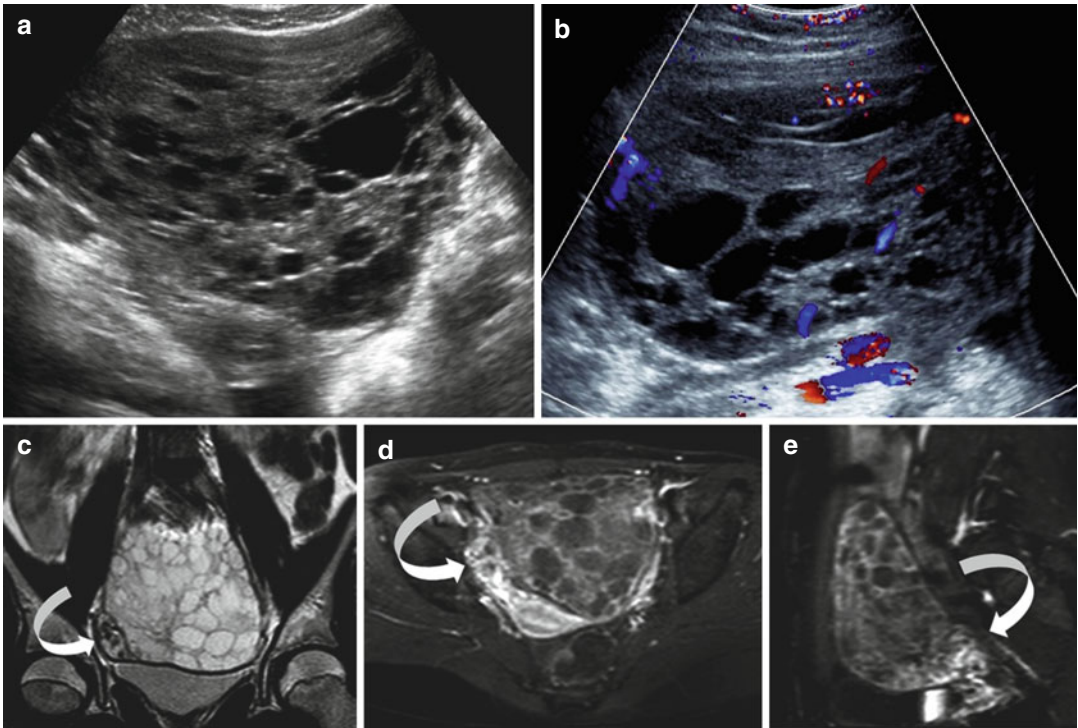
Massive ovarian edema in a 12-year-old girl with recurrent abdominal pain. (a) Transverse US shows a complex pelvic mass with multiple cystic areas. (b) At Color Doppler, the vascularization is preserved. (c) Coronal T2-weighted image shows an enlarged right
